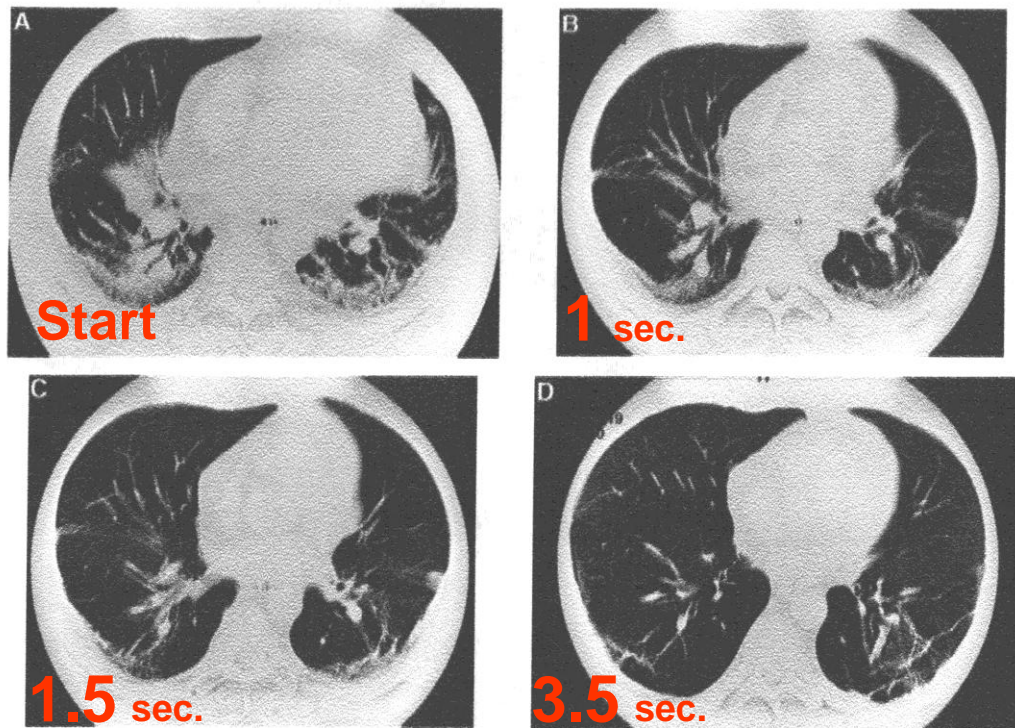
CT scan during the VC manoeuvre. A=At start of VC manoeuvre; B=1 s after the start of the VC manoeuvre; C=1.5 s after the start of the VC manoeuvre; and D=3.5 s after the start of the VC manoeuvre.
